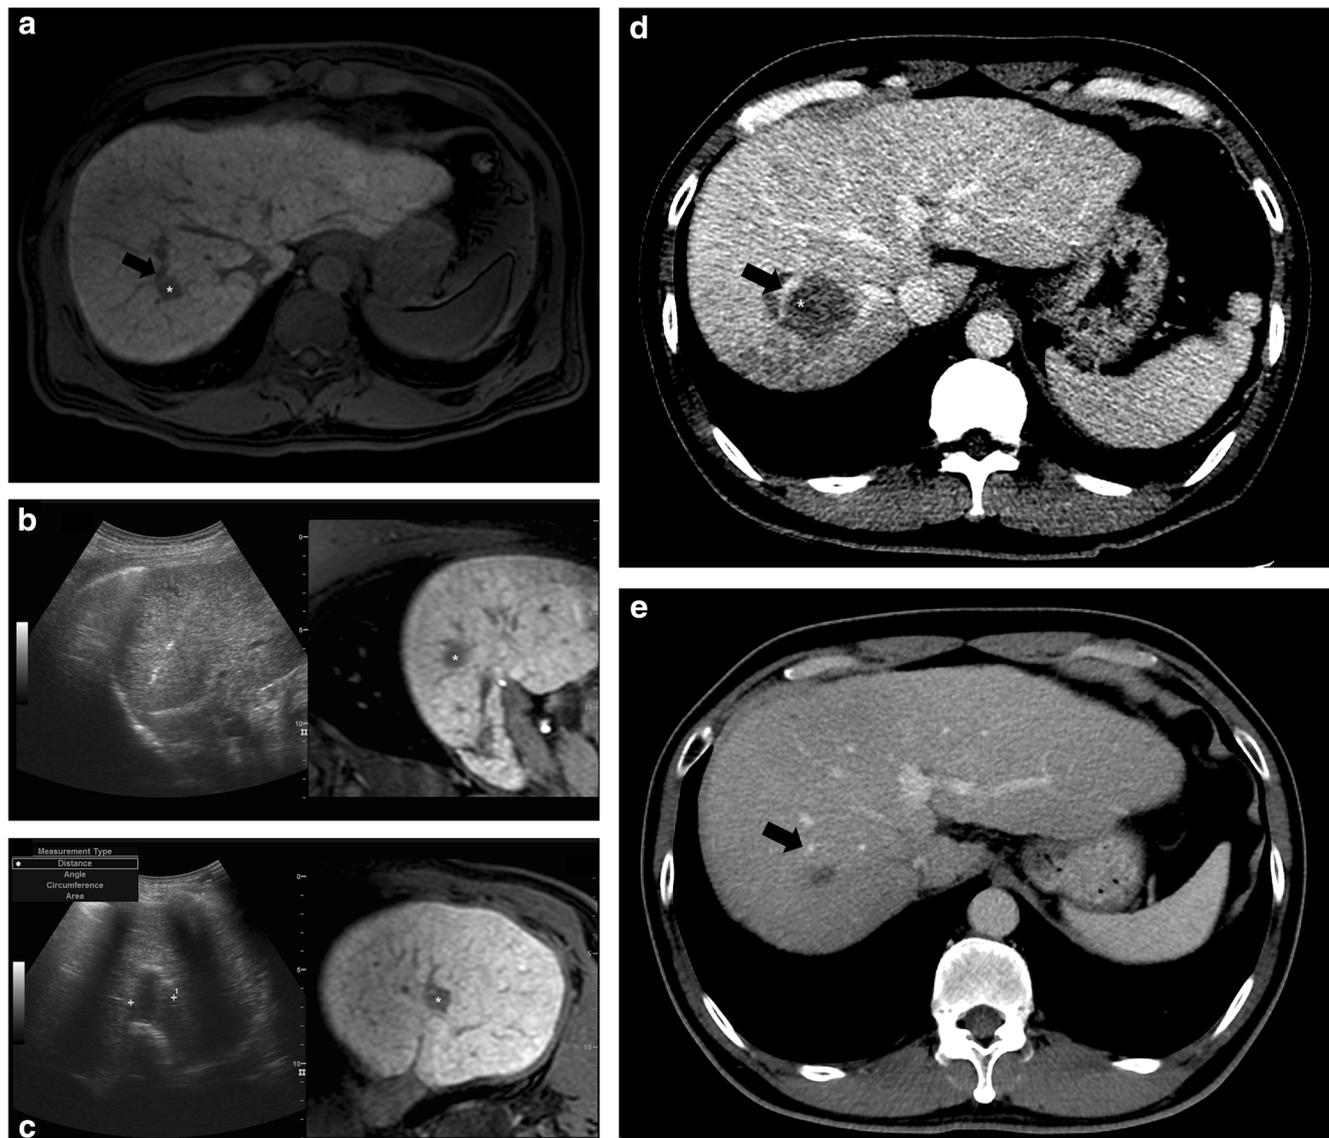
Images from a 54-year-old man who underwent cryoablation for perivascular HCC. (a) Axial MR image obtained during the hepatobiliary phase shows a 1.1-cm HCC (asterisk) in segment VII before cryoablation. The index tumour was adjacent to the portal vein (black arrow). (b) US imaging shows that the echogenic cryoprobe is located in the centre of the index tumour (asterisk). Two cryoprobes were inserted in parallel to evade the adjacent portal vein. (c) The anechoic area indicates the ice ball
